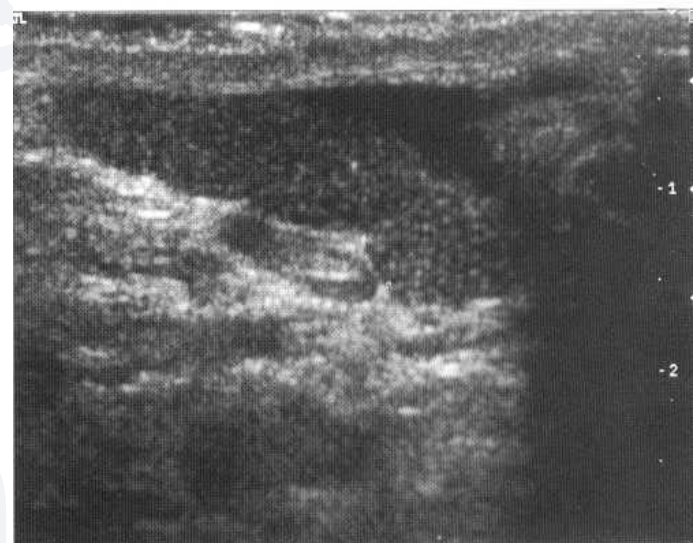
Ultrasound showing typical postvasectomy echo-poor epididymis.
